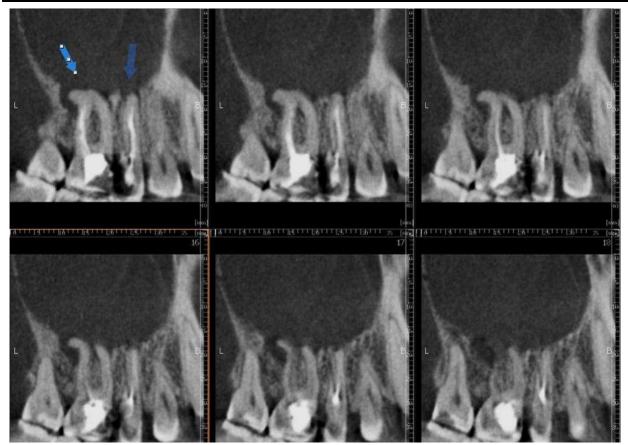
Iatrogenic maxillary sinusitis of stomatogenic origin (infectious-allergic form). A series of images of cone-ray computed tomography (sagittal section).
